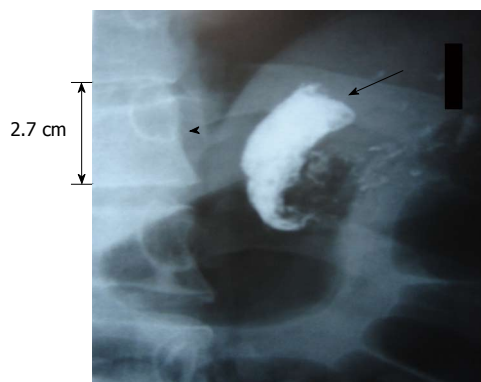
Erect X-ray, showing Dieulafoy large Arteriole after Iso Amyl-2-cyanoacrylate injection. It opens directly into the gastric cavity. Note the large caliber of the Arteriole (arrow) corresponding to the adjacent Lumbar Vertebra (arrow head).
